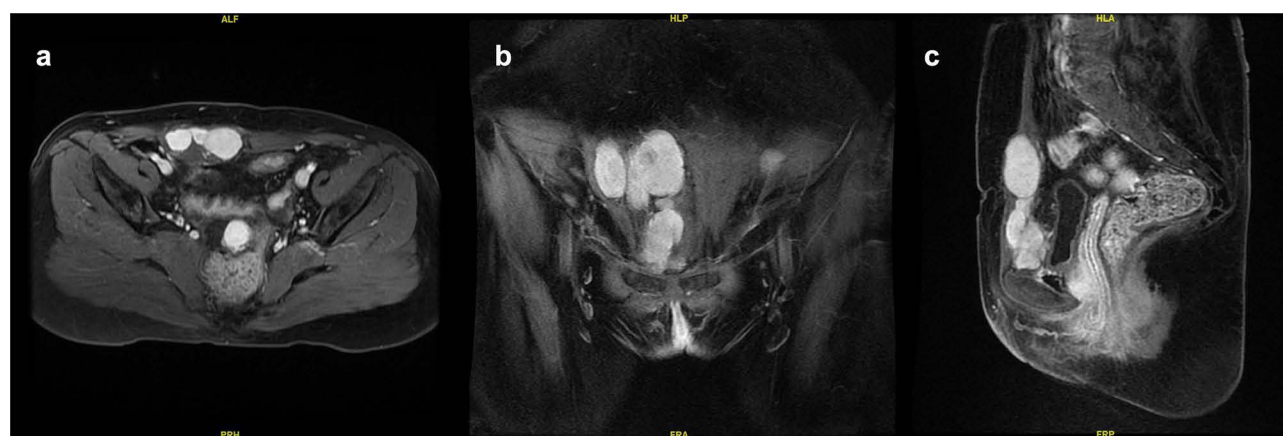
Pelvic magnetic resonance imaging findings. (a) Axial image showing multiple nodules in the lower anterior abdominal wall and a pelvic lesion anterior to the rectum. (b) Coronal image showing multiple nodules extending from the midline to the right lower abdominal wall/rectus region. (c) Sagittal image showing the spatial relationship between the abdominal wall lesions and the pelvic lesion anterior to the rectum. The lesions showed marked enhancement on contrast-enhanced MRI, and the largest abdominal wall lesion measured approximately 32 mm × 23 mm × 47 mm.
